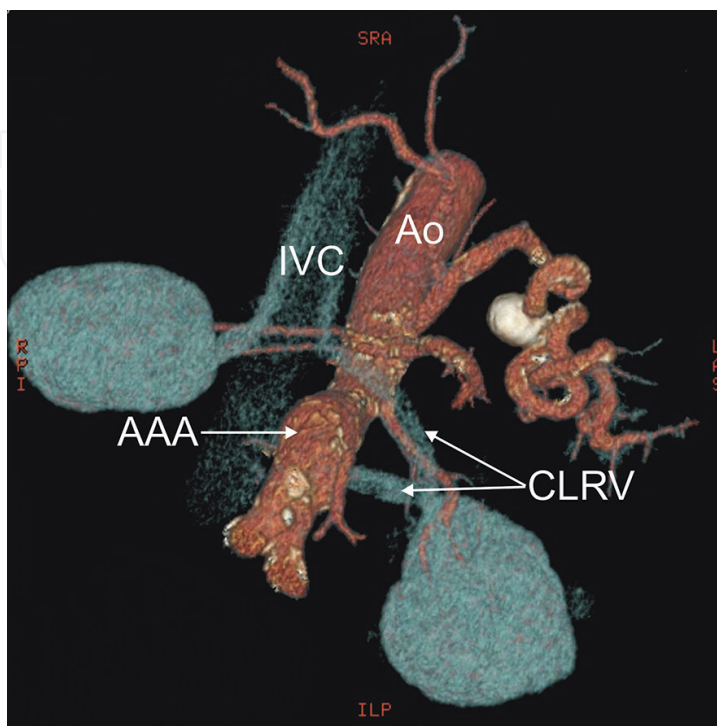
Three-dimensional computed tomography reconstruction of the vessels (CT-64-row MDCT scanner, Light-speed VCT, GE, Waukesha, Wisconsin, USA). Ao: aorta, AAA: abdominal aortic aneurysm, CLRv: circumaortic left renal vein, IVC: inferior vena cava.
